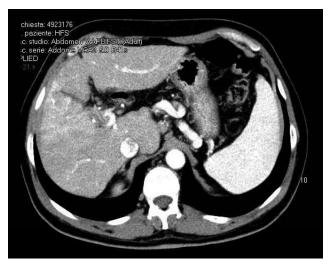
The computed tomography scan shows an hypervascular area corresponding to hepatocellular carcinoma with neoplastic right portal vein thrombosis before yttrium-90 microspheres treatment.
